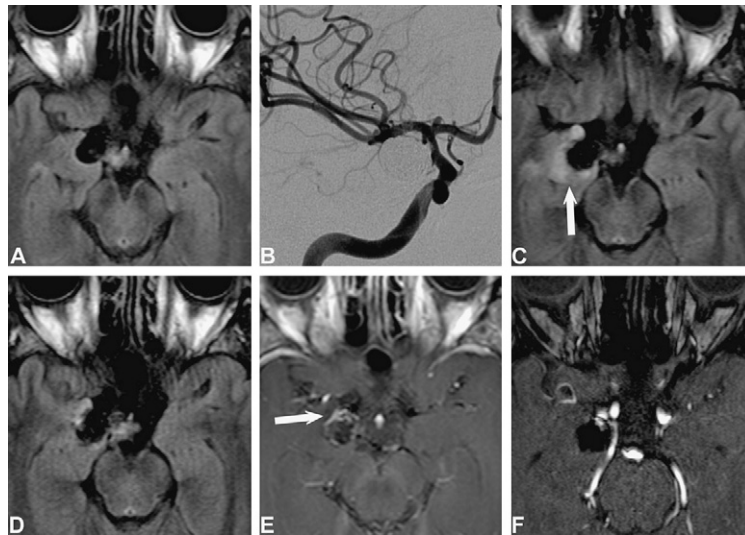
Magnetic resonance imaging and Digital subtraction angiography (DSA). A. FLAIR sequence, before embolization, shows no perianeurysmal edema. B. Angiographic control at the end of the procedure, after placing 12 bare platinum coils, shows complete occlusion of the aneurysm. C. FLAIR sequence, 3 months after embolization, demonstrating the perianeurysmal edema (arrow). D and E. FLAIR sequence and T1 with gadolinium injection, 6 months after embolization, demonstrate marked improvement of perianeurysmal edema but thin wall enhancement (arrow). F. TOF sequence 6 months after embolization reveals a small neck remnant, which is stable compared to the 3-month control.
